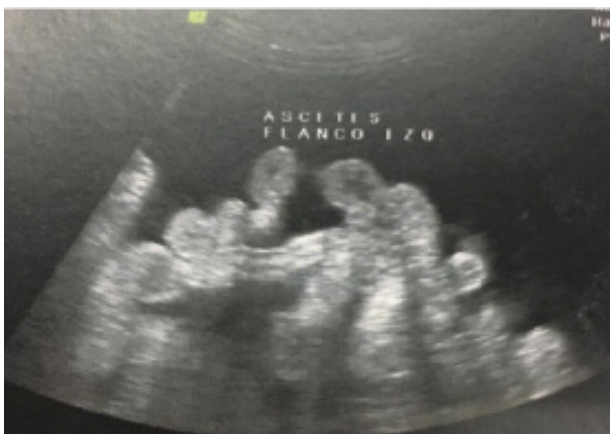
Massive ascites with small intestine floating inside the peritoneal cavity visualized on transabdominal ultrasound.
